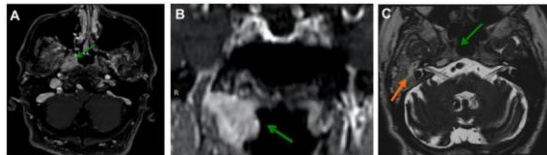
A, Postcontrast T1 axial & coronal magnetic resonance imaging (MRI) demonstrating an ill-defined enhancing lesion (green arrow) occupying the right nasopharyngeal wall B, Axial T2 MRI demonstrating minimal to mild mass effect, hypointensity, and moderate homogeneous enhancement after contrast administration. Intact nasopharyngeal mucosa with no lymphadenopathy. Fluid opacification of the right mastoid air cells owing to Eustachian tube obstruction (orange arrow) (3C)
